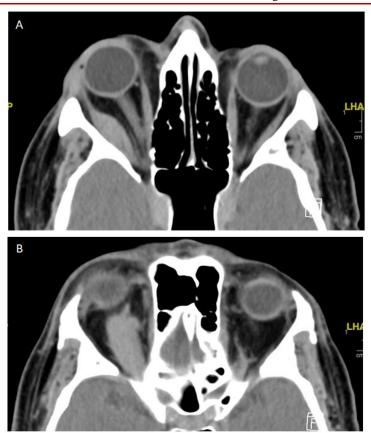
CT scans of the orbits with axial views showing (A) and (B) thickening of the right superior and lateral rectus muscles with mild stranding of intra-orbital fat
